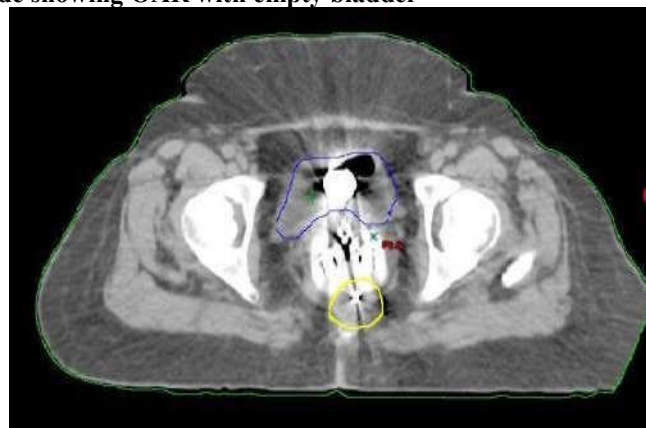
Transaxial CT slide showing OAR with empty bladder
